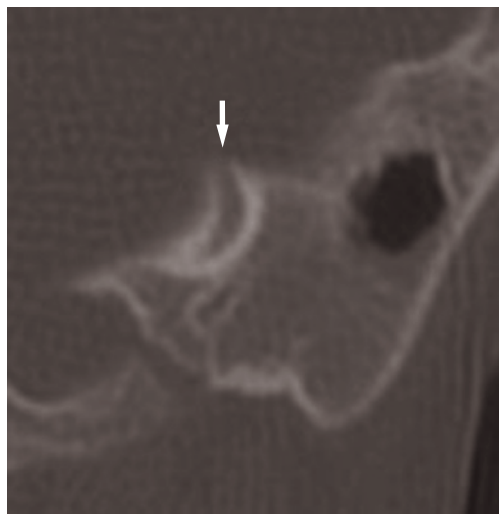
Coronal CT scan. Superior semicircular canal dehiscence: defect of bony wall (arrow).
